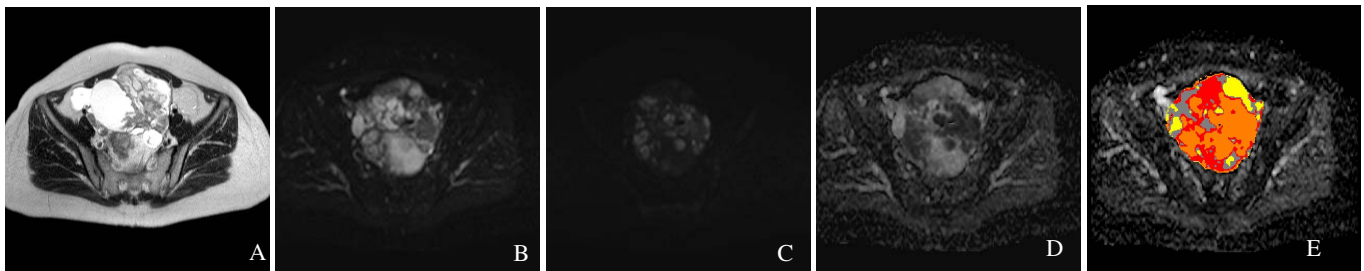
(a) T2-weighted image and (b) b=0 image show a complex mass that is hyperintense on the b=1000 DW image (c); the ADC map (d) confirms the multicomponent nature of the tumor, while the colored-ADC map displays the principal ADC components after segmentation
